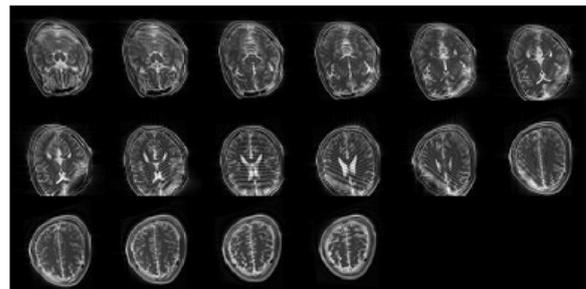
An example of geometric distortion in brain MRI scans [8]
